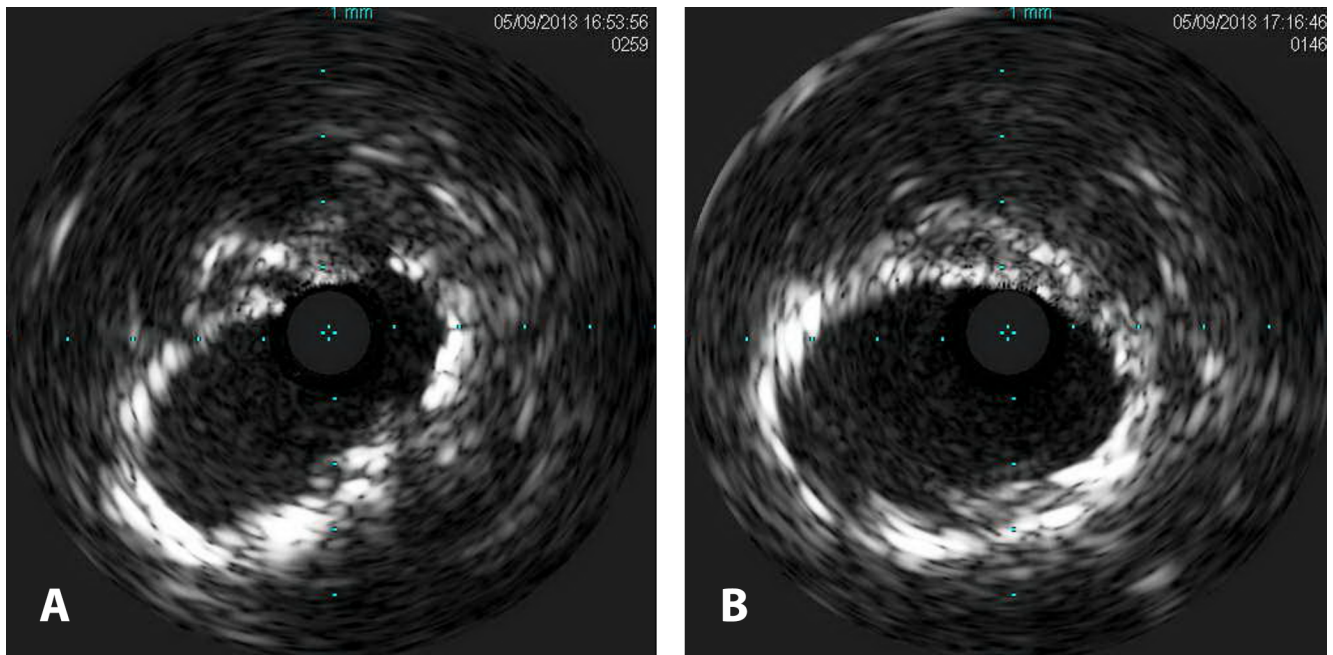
Intra vascular ultrasound demonstrating after initial stent placement demonstrating an ellipsoid geometry after initial stent placement (*Panel A*) and improved geometry after second stent placement (*Panel B*).
